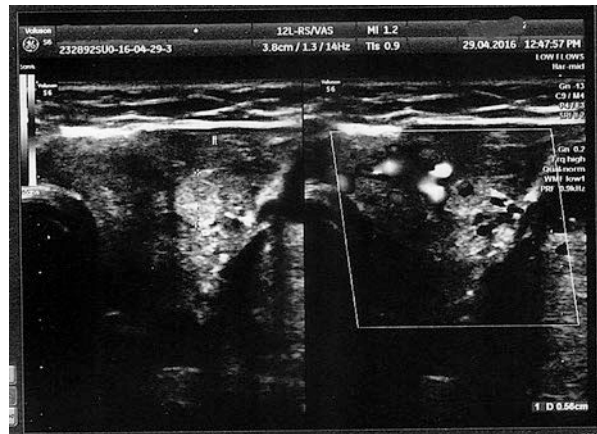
Ultrasound: Thyroid gland
